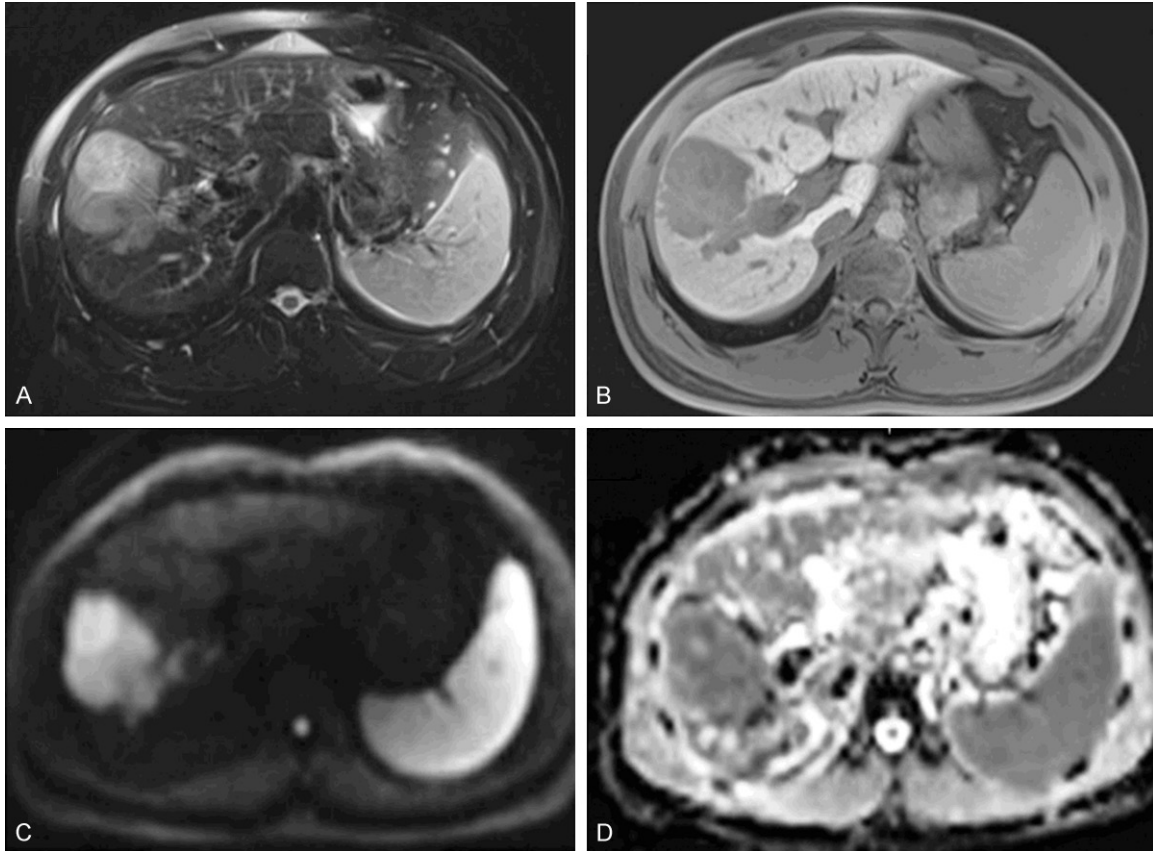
MRI of a 31-year-old male patient with a pathologically verified hepatocellular carcinoma of Edmondson-Steiner grade III. The patient suffered intrahepatic recurrence at 8 months after tumor resection. A 6.3 cm tumor in right lobe of the liver shows heterogeneous hyperintensity on T2-weighted image (A), hypointensity on 20-min hepatobiliary phase (B) and restricted diffusion on the diffusion-weighted image with a b -value of 700 s/mm² (C). ADC (D) shows lower signal intensity compared with that of liver parenchyma. [Reproduced with permission from reference [51]].
